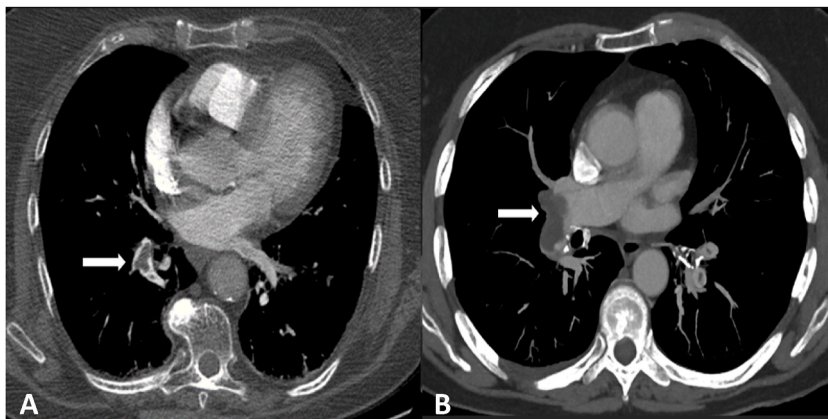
Axial CTA images (A and B) demonstrate some endoluminal filling defects of pulmonary arterial vessels in CTA (arrows), often referred to as CPE.
